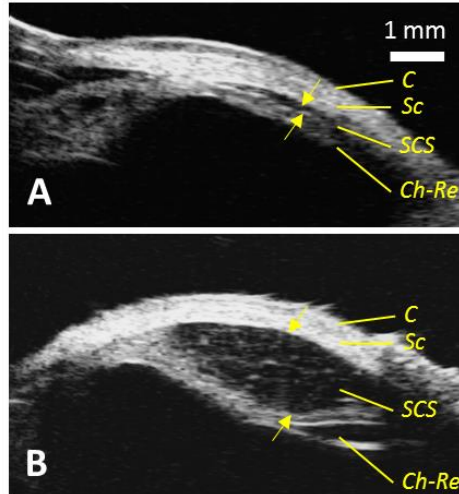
Representative ultrasound B-scan images of the SCS after 50  $\mu\text{L}$  injection of (A) HBSS and (B) 5% CMC solution. C = conjunctiva; Sc = sclera; SCS = suprachoroidal space; Ch-Re = choroid-retina. Arrows indicate SCS thickness.
